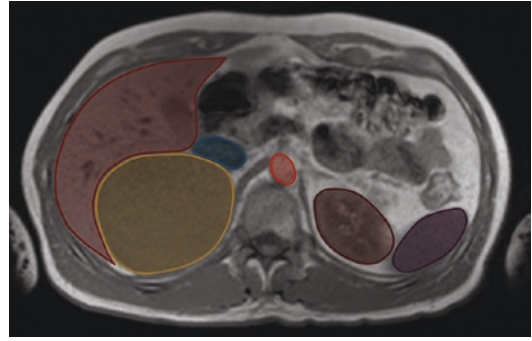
MRI—axial plane. An 11-cm giant cyst of the right adrenal gland (yellow) is pushing the right lobe of the liver (light brown). The cyst pushes and flattens the IVC (blue). Aorta (red). Left kidney (dark brown). Spleen (purple)
